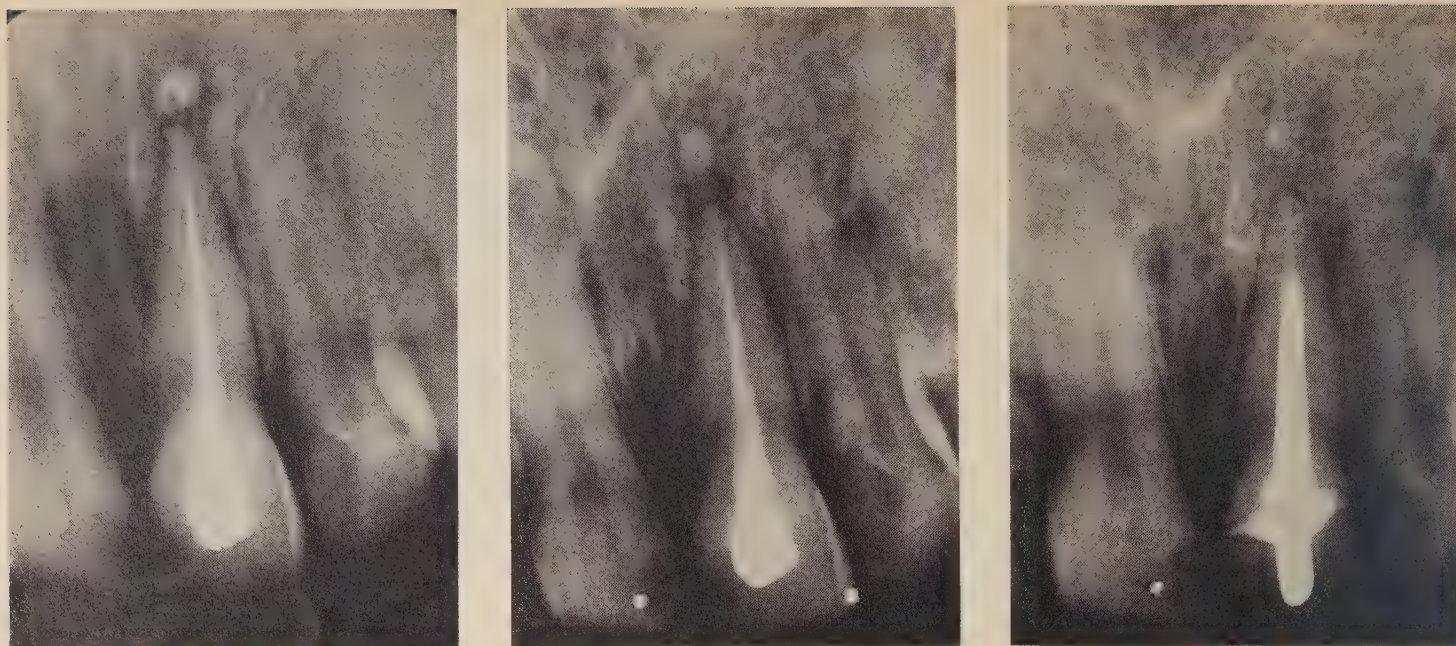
Response to polycarboxylate root canal cement. Left: the material was used to fill the root canal of an upper incisor in 1966. Some cement escaped into the periapical region. Centre: appearance one year later. Right: appearance two years later.
